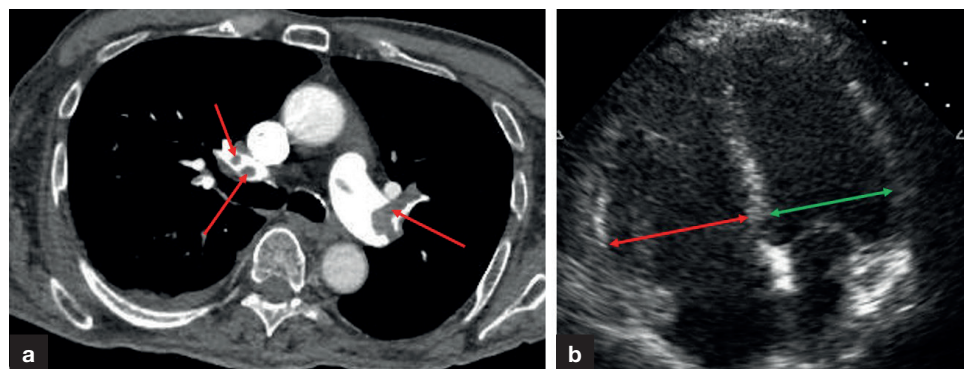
a. Computed tomography pulmonary angiogram showing bilateral pulmonary emboli. b. Echocardiogram showing a dilated right ventricle.
